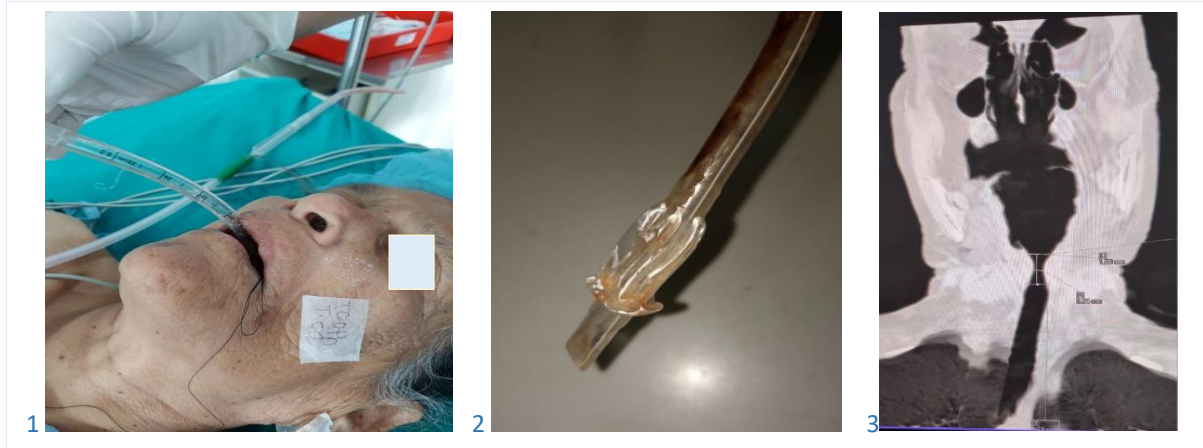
A fully awake patient with a stuck ET tube after surgery; Figure 2. Endotracheal tube after extubation showing a complete ring formation at the distal end; Figure 3. A CT scan of airway after removal of stuck ET tube
